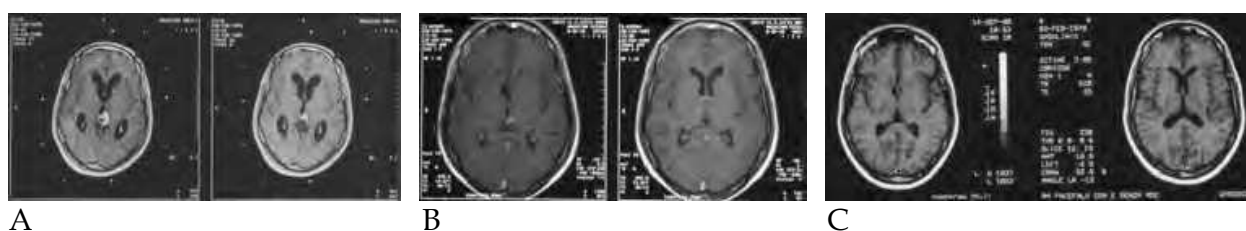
A) Posterior III ventricle pineocytoma on GKRS day. The diagnosis was achieved by means of stereotactic neuroendoscopy biopsy. B) MR imaging follow-up at 3 months and C) at 18 months from GKRS showing the gradual disappearance of the tumor.
